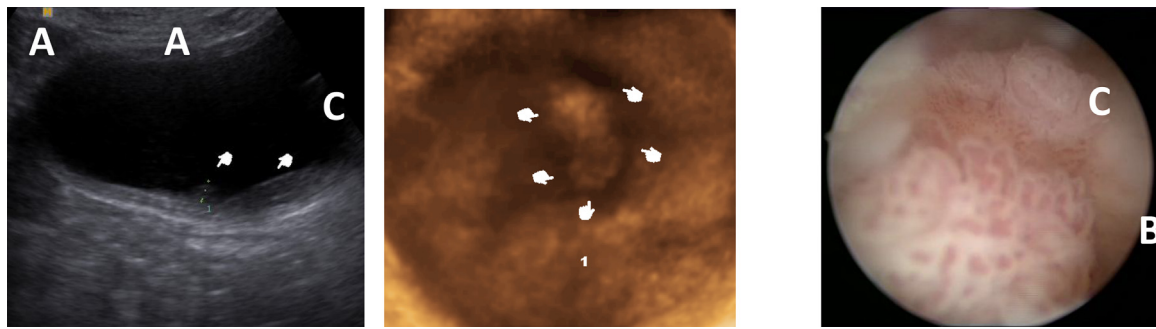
Ultrasonographic examination before the second conventional cystoscopy (6 month follow up) in a 74 years old man with a history of bladder cancer treated by transurethral resection. (A) Transverse grey scale ultrasonography showing thickening of the posterior wall of the urinary bladder with small papillary projections (white pointers) into the lumen. (B) Real-time three dimensional ultrasonography based virtual cystoscopy showing a broad-based elevated lesion (pointers) at the posterior wall. (C) Conventional cystoscopic appearance of the same lesion. Transurethral resection and biopsy revealed low grade superficial transitional cell carcinoma.
